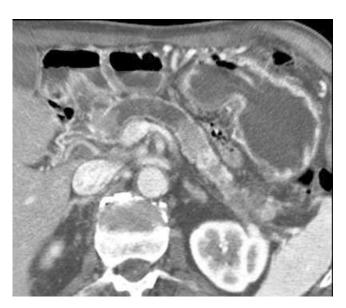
Contrast-enhanced CT scan shows a markedly dilated main pancreatic duct with pancreatic parenchymal atrophy. Multiple areas of soft tissue growth are seen within the pancreatic duct consistent with multifocal cancer arising in main duct IPMN.
